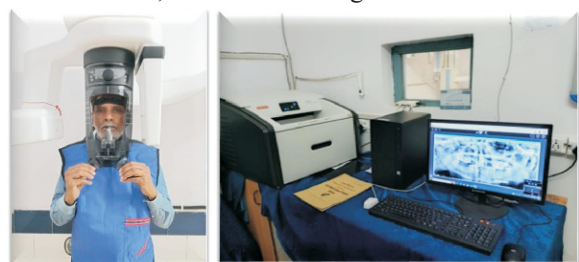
(a) Placement of patient for radiograph, (b) Analyzing the radiograph using GIMPS software
